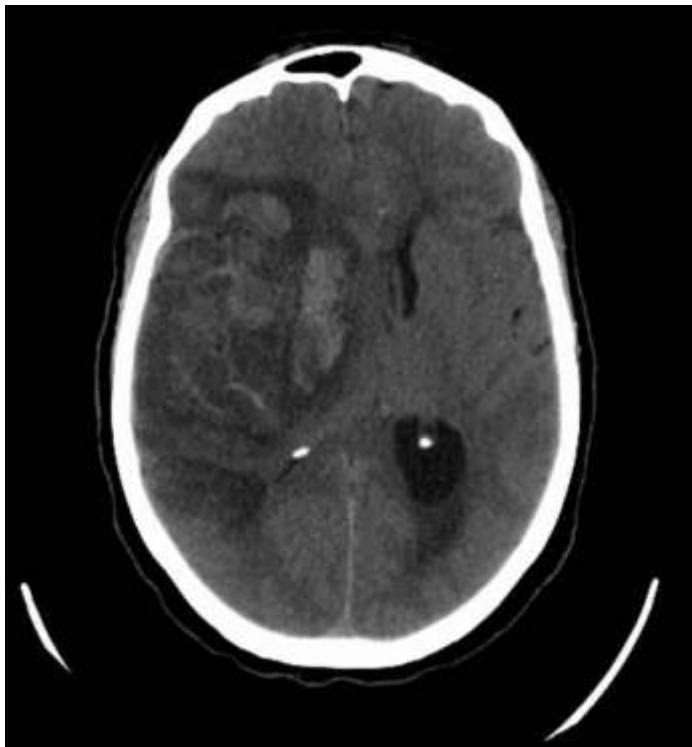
Brain CT-scan: hemorrhagic transformation of an ischemic lesion due to a right MCA occlusion.
